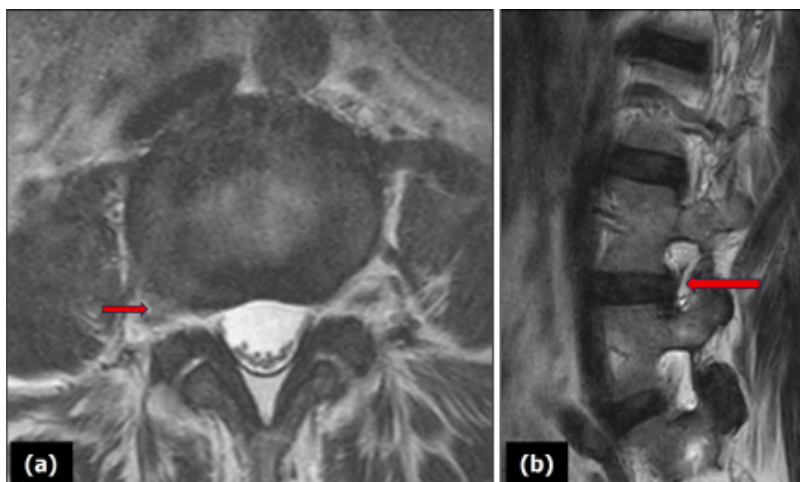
Lumbosacral spine MRI. (a) Axial T2-weighted image at the L3/L4 level reveals a mild right paracentral disc protrusion (red arrow), which impinged on the adjacent exiting and traversing nerve roots; (b) The corresponding sagittal T2-weighted image confirmed the disc pathology (red arrow), demonstrating the relationship of the protrusion to the neural structures within the spinal canal
